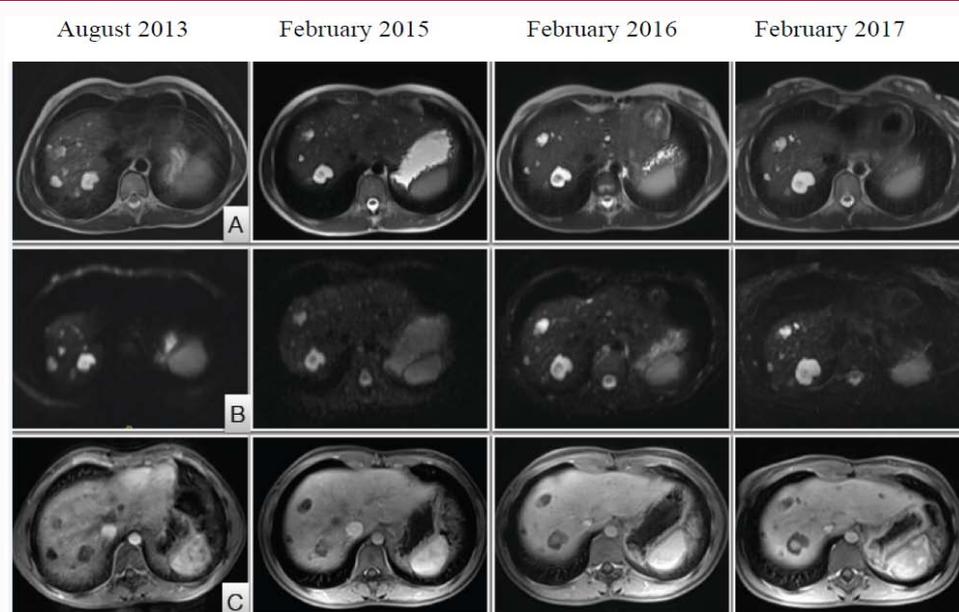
MRI: A) T2, B) DWI (Diffusion Weighted Imaging), C) VIBE (3D-Volumetric Interpolated Breath-hold Examination) sequence dynamic contrast-enhanced scan.
